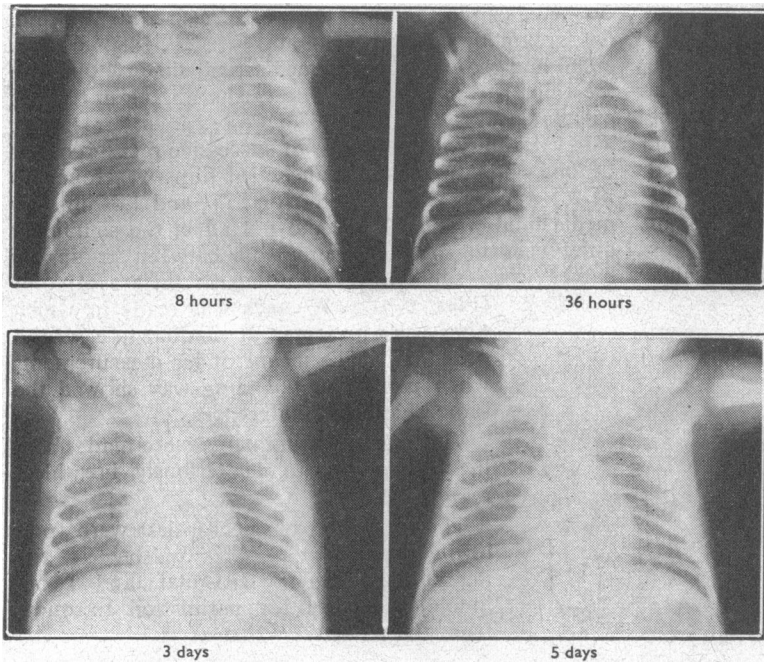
Baby H., 2 lb. 13 oz. (1,275 g.), showing diminishing heart size and mediastinal width during recovery from severe dyspnoea. Radiographs taken at 8 hours, 36 hours, 3 days, and 5 days.
